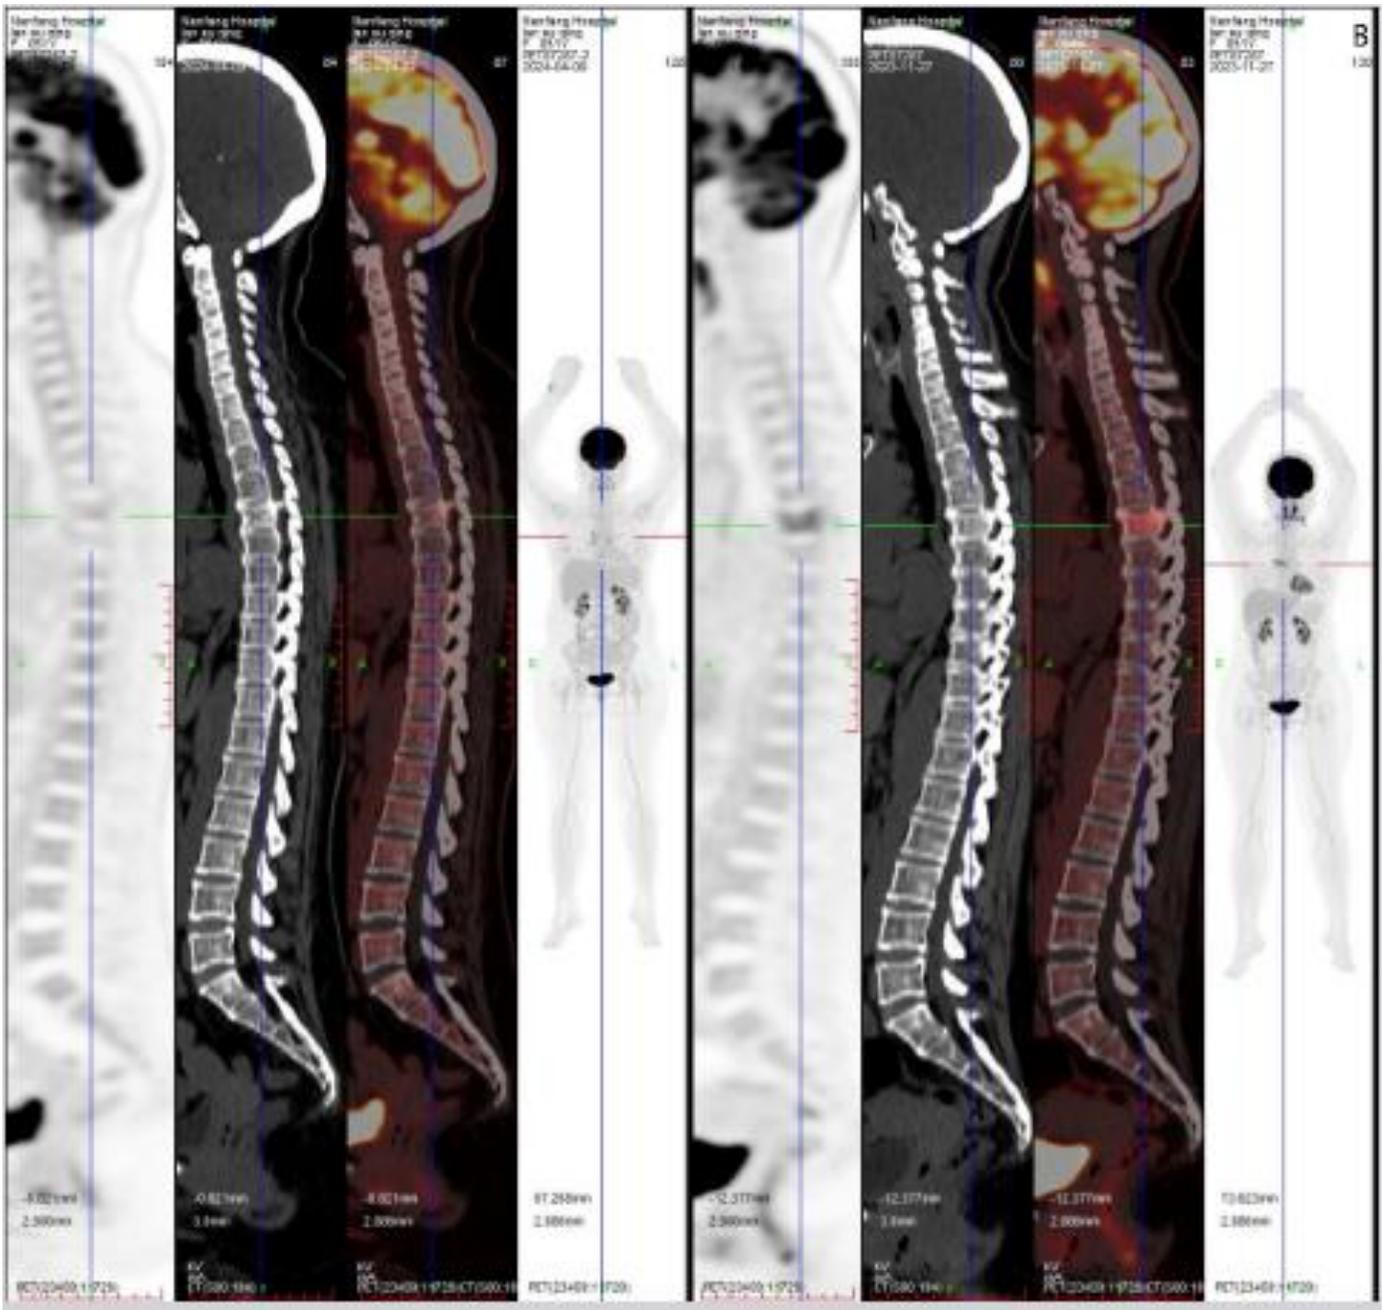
PET/CT findings of the patient with plasmablastic lymphoma
